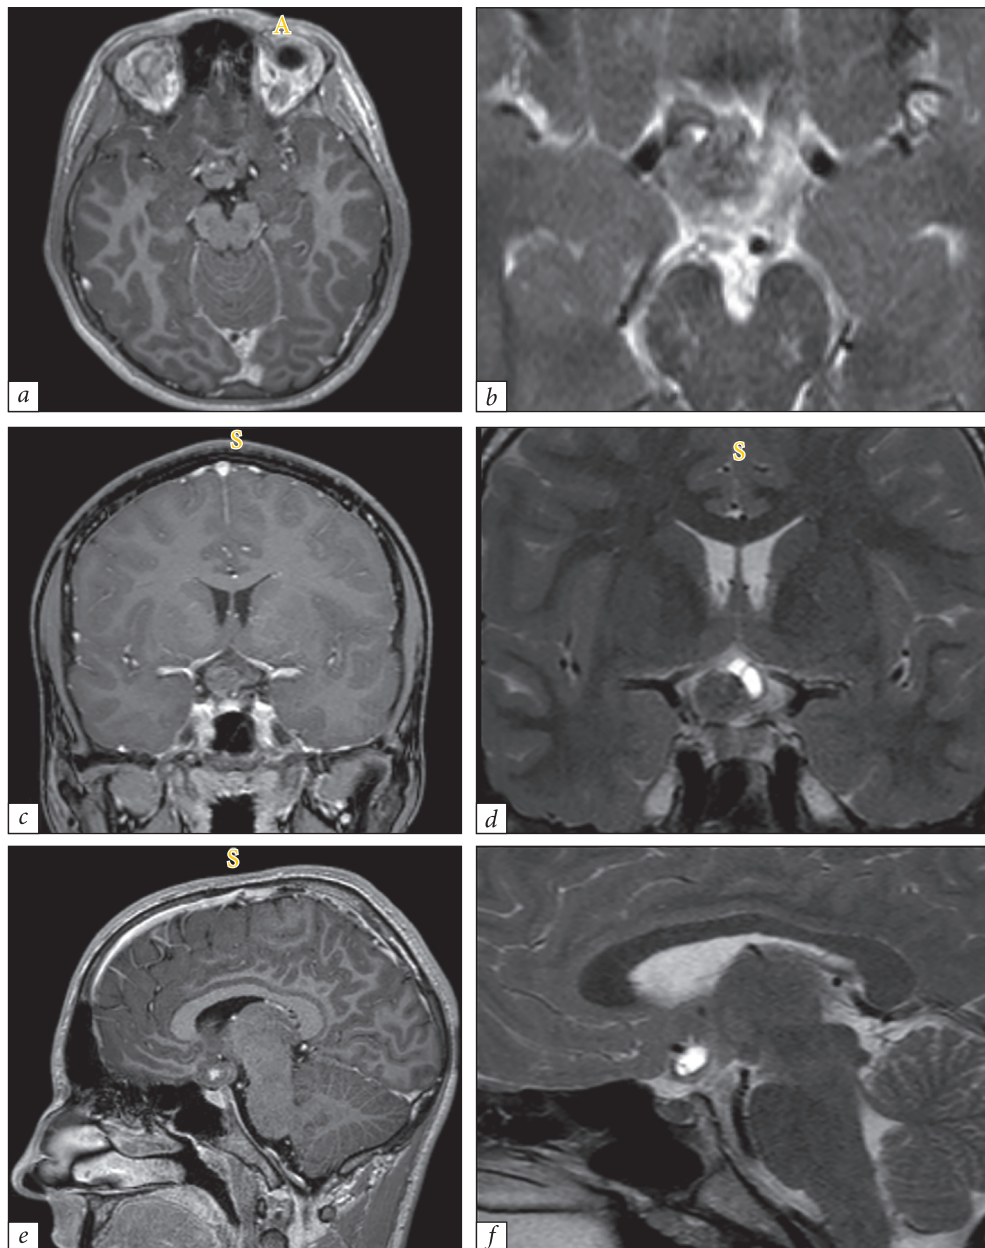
Characteristics of capillary hemangiomas. There is a heterogeneous signal on T2-weighted images (right column, *b, d, f*), which remains unchanged after contrast administration, and a heterogeneous hyperintense signal on T1-weighted images (left column, *a, c, e*; white arrowheads). From above to below, *a* and *b* represent an axial, *c* and *d* — coronal, *e* and *f* — sagittal view, respectively
